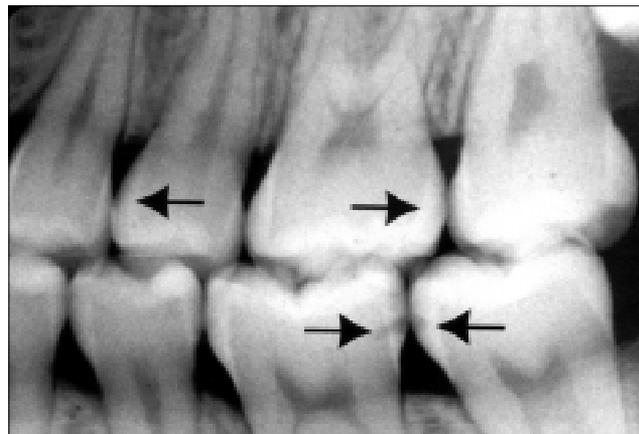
Case 1: 15 year, 5-month-old female. Left bitewing radiograph.
